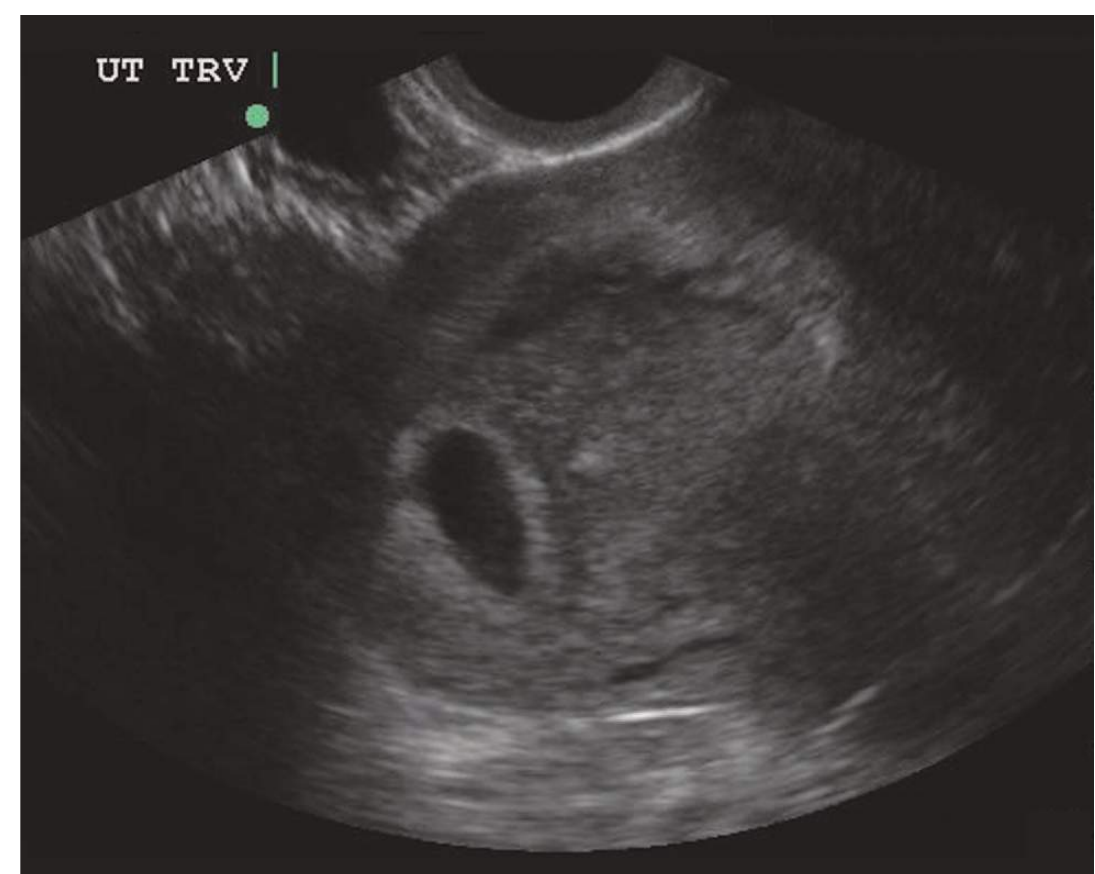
■ Intrauterine Gestational Sac. Discrete ring of an intrauterine gestational sac seen on transvaginal ultrasound. No yolk sac is visualized. A double decidual sac sign is seen, lending evidence of a true gestational sac versus a pseudogestational sac formed from a decidual cast in ectopic pregnancy. A thorough look in the adnexa is important in diagnosing ectopic pregnancy when a gestational sac is the only finding. (Photo contributor: Lauren Oliveira, DO.)
